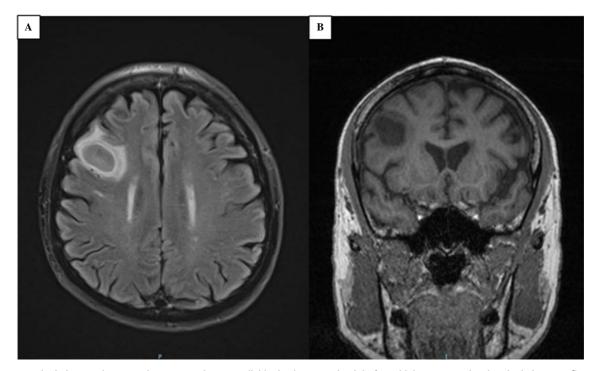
MRI brain images demonstrating presumptive Nocardial brain abscess at the right frontal lobe on coronal and sagittal views. A: Coronal view of MRI brain showing 2.3 cm \times 2.1 cm \times 1.3 cm solitary, well-circumscribed, lesion demonstrating restricted diffusion, T2-weighted hyperintensity and T1-weighted hypointensity that is consistent with a cerebral abscess. Mild surrounding vasogenic edema without significant mass effect is seen. B: Sagittal view showing the same lesion in the frontal lobe.
